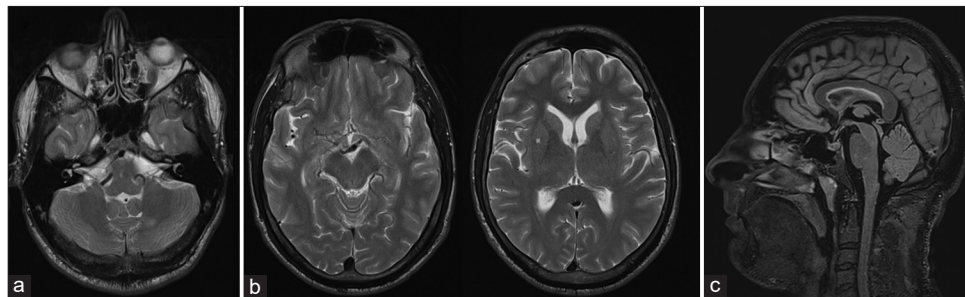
Magnetic resonance imaging 6 weeks later demonstrating resolution of signal change and swelling of the infratentorial structures and improvement of hydrocephalus (a and c). Occasional T2 hyperintensities in supratentorial white matter persist, presumably due to mild small vessel disease (b).
